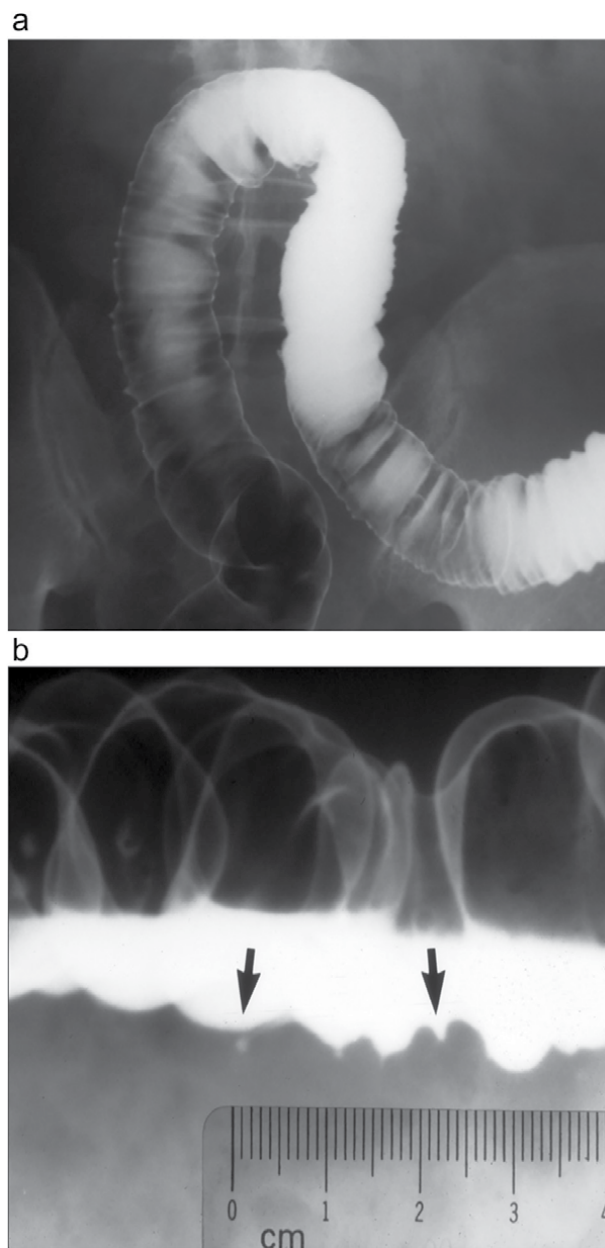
Radiological appearance of early intramural diverticulosis in a 52-year-old man. A. Barium enema examination shows the serrated margins of the sigmoid loop caused by thorn-like mucosal protrusions into the wall. B. Magnified radiograph of the descending colon demonstrates several 1–2 mm diverticula (arrows). Source: [10].
